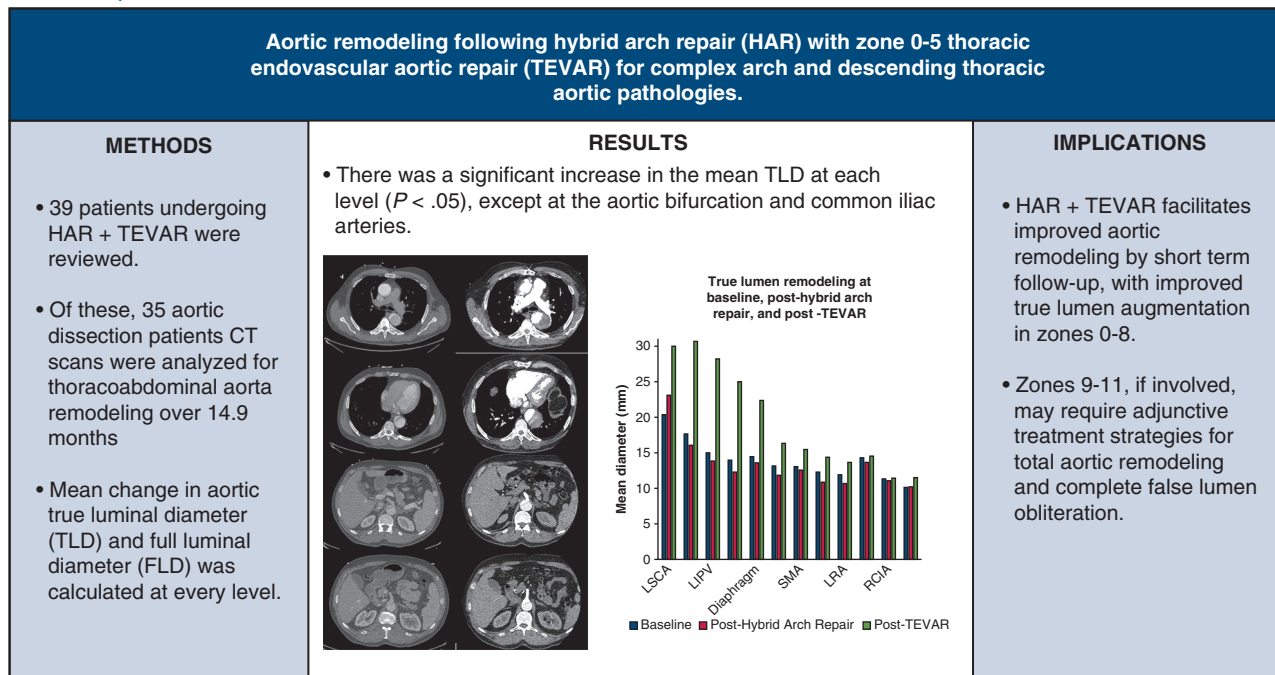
Graphical Abstract. Graphical summary of our analysis with representation of true and full lumen remodeling. TLD, True lumen diameter; CT, computed tomography; LSCA, left subclavian artery; LIPV, left inferior pulmonary vein; SMA, superior mesenteric artery; LRA, left renal artery; RCIA, right common iliac artery
